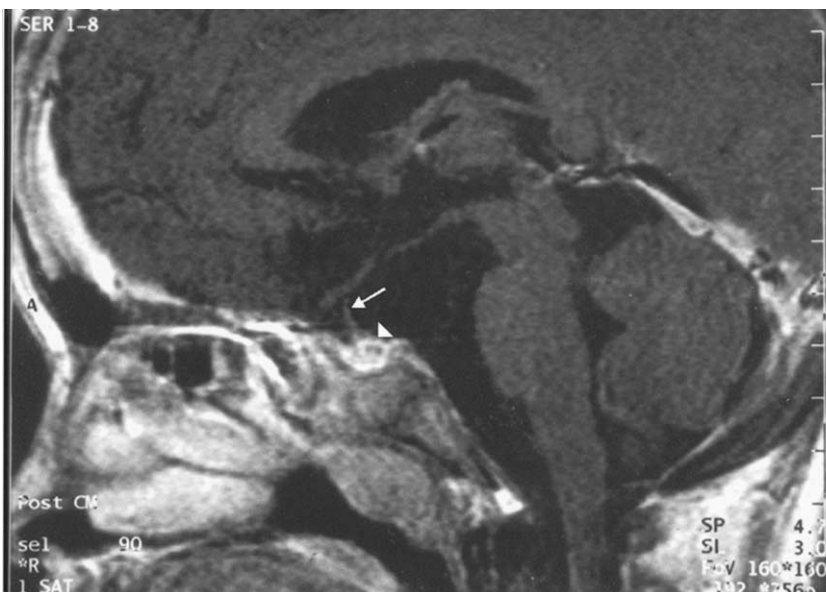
Sagittal T_1 -weighted magnetic resonance image with gadolinium enhancement (TR = 500 ms, TE = 14 ms) demonstrated poorly enhanced hypothalamus, displaced and distorted pituitary stalk (arrow), and normal-sized pituitary gland (arrowhead).
